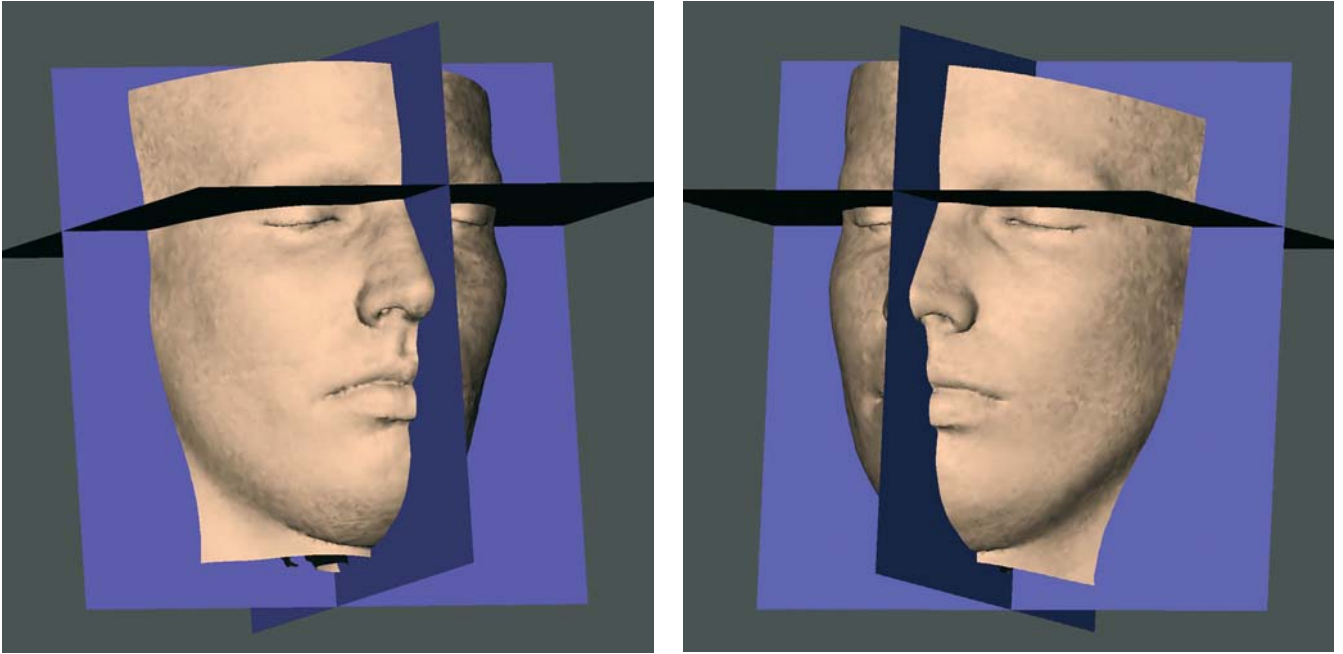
a, b. 3-D cephalometric reference system superimposed on the soft tissue surface representations (3-D CT, patient K.C.)
